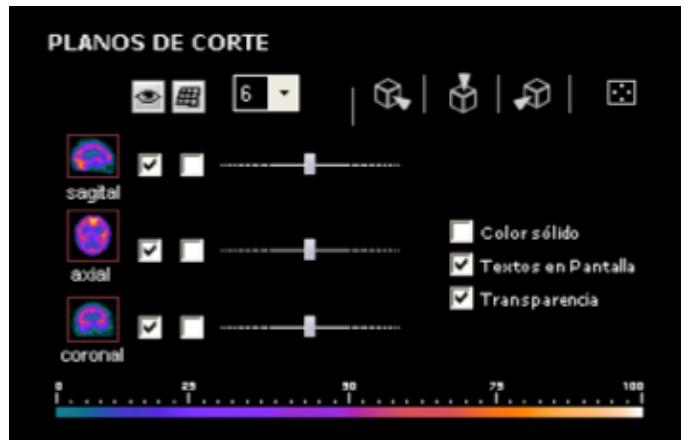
Plane cut control detail of the anatomical functional viewer. It includes access icons to predefined views (upper right region), that enable focusing on the scene orienting the camera and scrollbar for the selection of different plane cut levels and finally selecting the “rejilla” option for calculating distances within each SPECT section. Notice the numerical box which specifies the row and column number that will define the grating quadrants.
